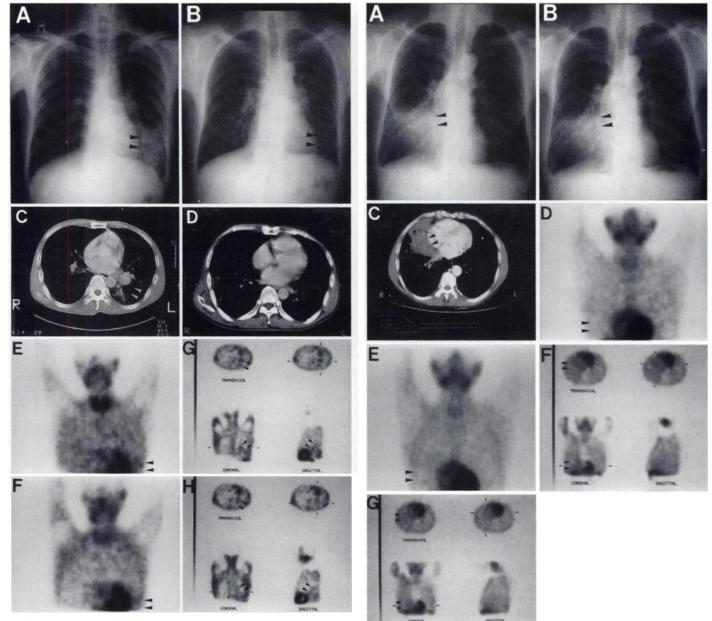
Complete response. A tumor mass in the left lower lung (black arrow heads, (A) was completely resolved after three courses of VAP chemotherapy (black arrowheads, (B). CT images before (C) and after (D) chemotherapy show disappearance of tumors (white arrowheads). Both 1 hr (E) and 4 hr (F) ^{99m}Tc-MIBI planar images show hot uptakes in the left lower lung (black arrowheads). One hour (G) and 4 hr (H) tomographic images of ^{99m}Tc-MIBI show hot uptakes in the tumor (small black arrowheads). Apparent washout of ^{99m}Tc-MIBI is noted in both planar and tomographic images.
